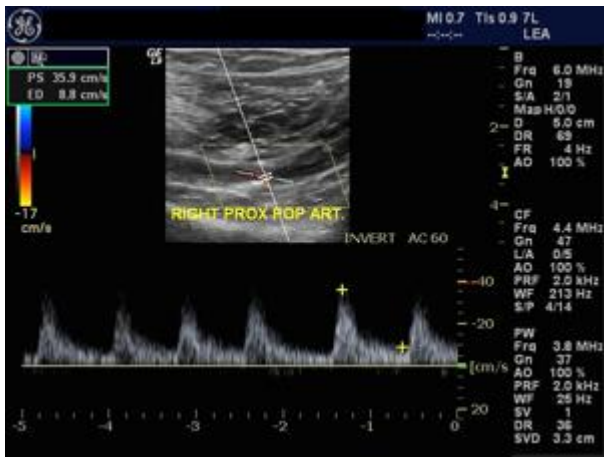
Color and Spectral Doppler image of Right Proximal Popliteal Artery.
